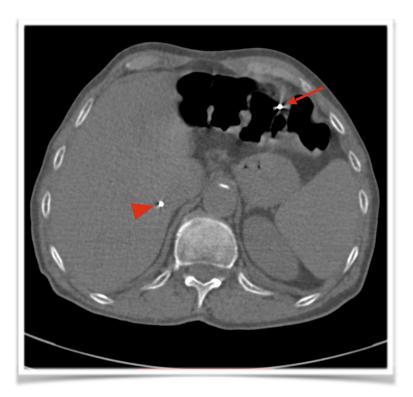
Axial nonenhanced CT image at the level of L1 vertebra showing the pacing the lead in the inferior vena cava (arrowhead) and the distal end (arrow) of the pacing lead in the peritoneal cavity.
